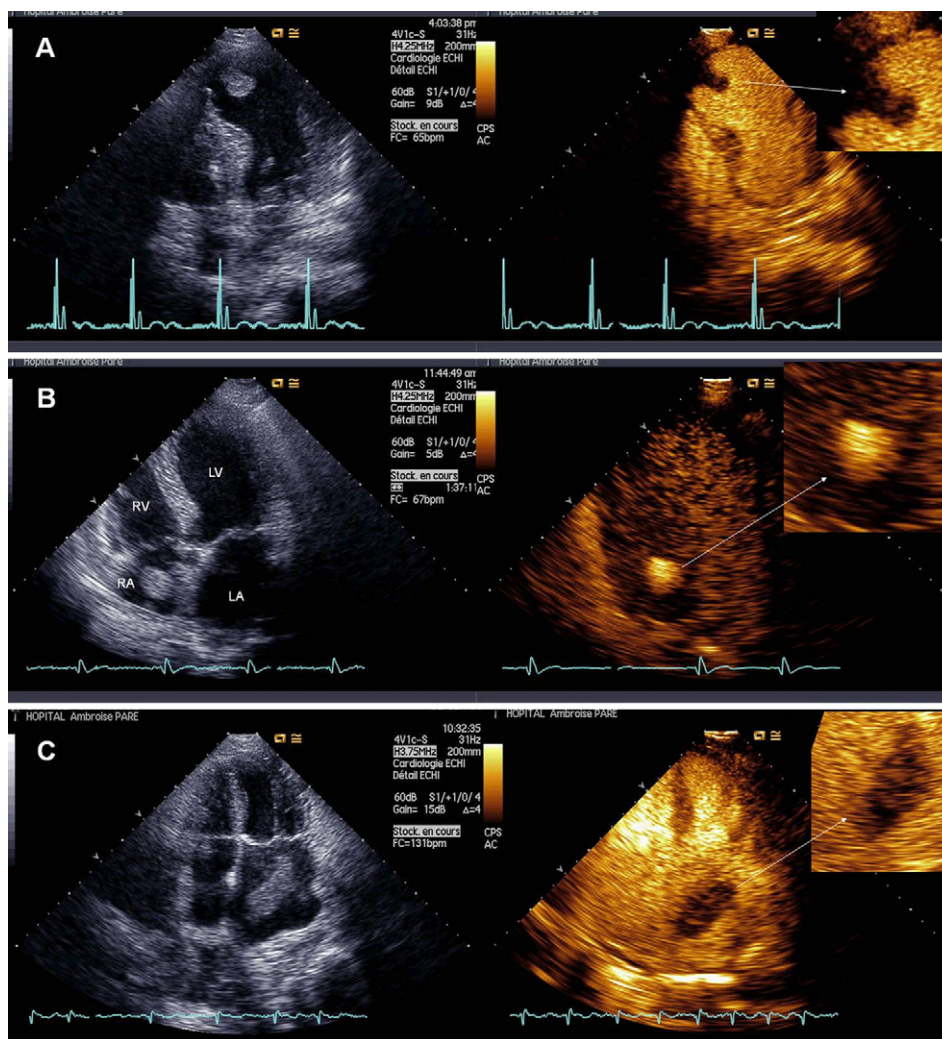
Three examples of intracardiac mass in apical 4-chamber view according to the results of contrast echocardiography. A. Left ventricular apical thrombus in a patient with a history of myocardial infarction. Contrast echocardiography revealed no enhancement of the mass. B. Secondary cardiac tumour (renal sarcoma) located in the RA, with a complete enhancement of mass by contrast agent. C Left atrial myxoma, with a partial enhancement of mass by contrast agent.
